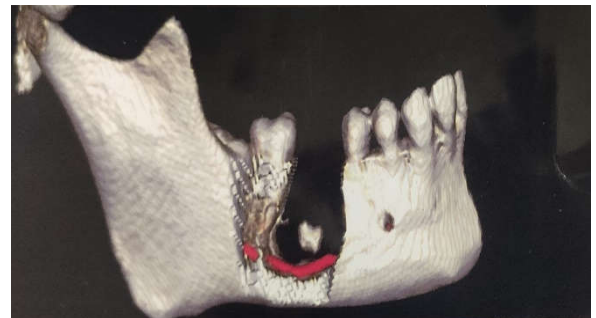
CBCT 3D Reconstruction (Sagittal cut)
